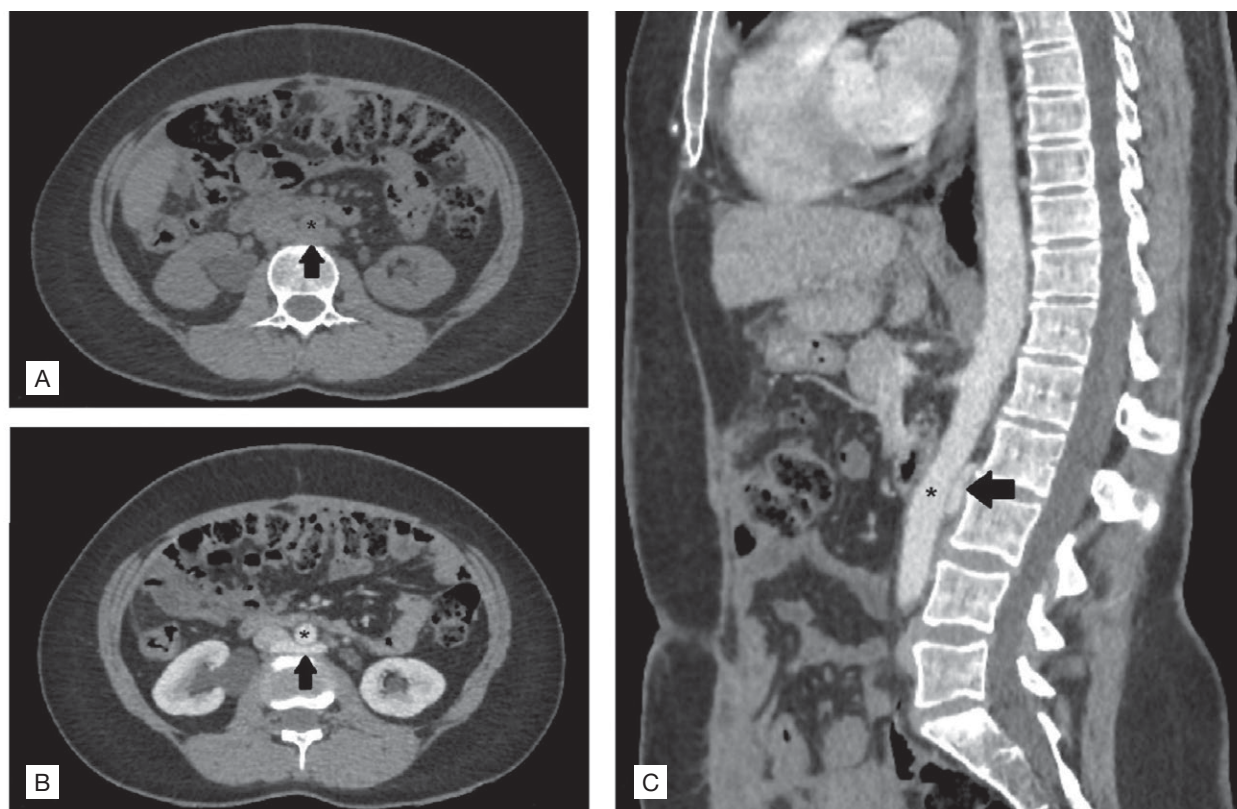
Non-contrast CT scan in the axial section in A showing retro-aortic left renal vein (black arrow) compressed by the abdominal aorta (black asterisk). CT scan with contrast in the arterial phase in the axial section in B and in the sagittal section in C demonstrating the retro-aortic left renal vein (black arrow) compressed by the abdominal aorta (black asterisk).
